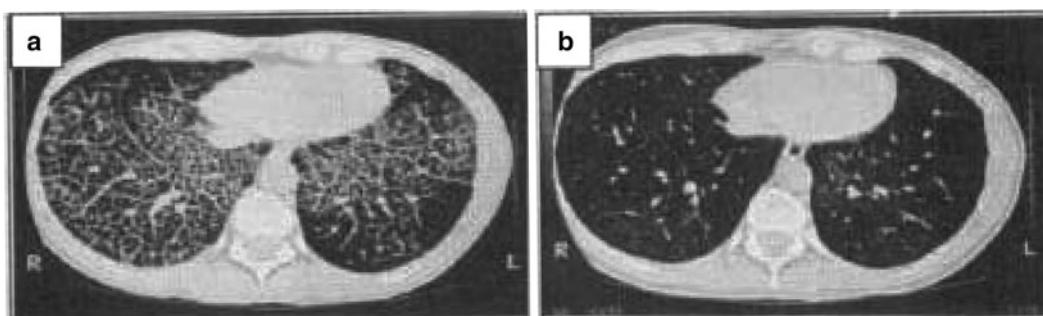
Radiological imaging. (a) Chest CT scan before WLL, note the important amount of alveolar material looking like "crazy-paving." (b) CT scan 3 days after WLL, the alveolar material has been cleared out. (Reprinted from Bussières [8]. © 2001 with permission from Elsevier.).
